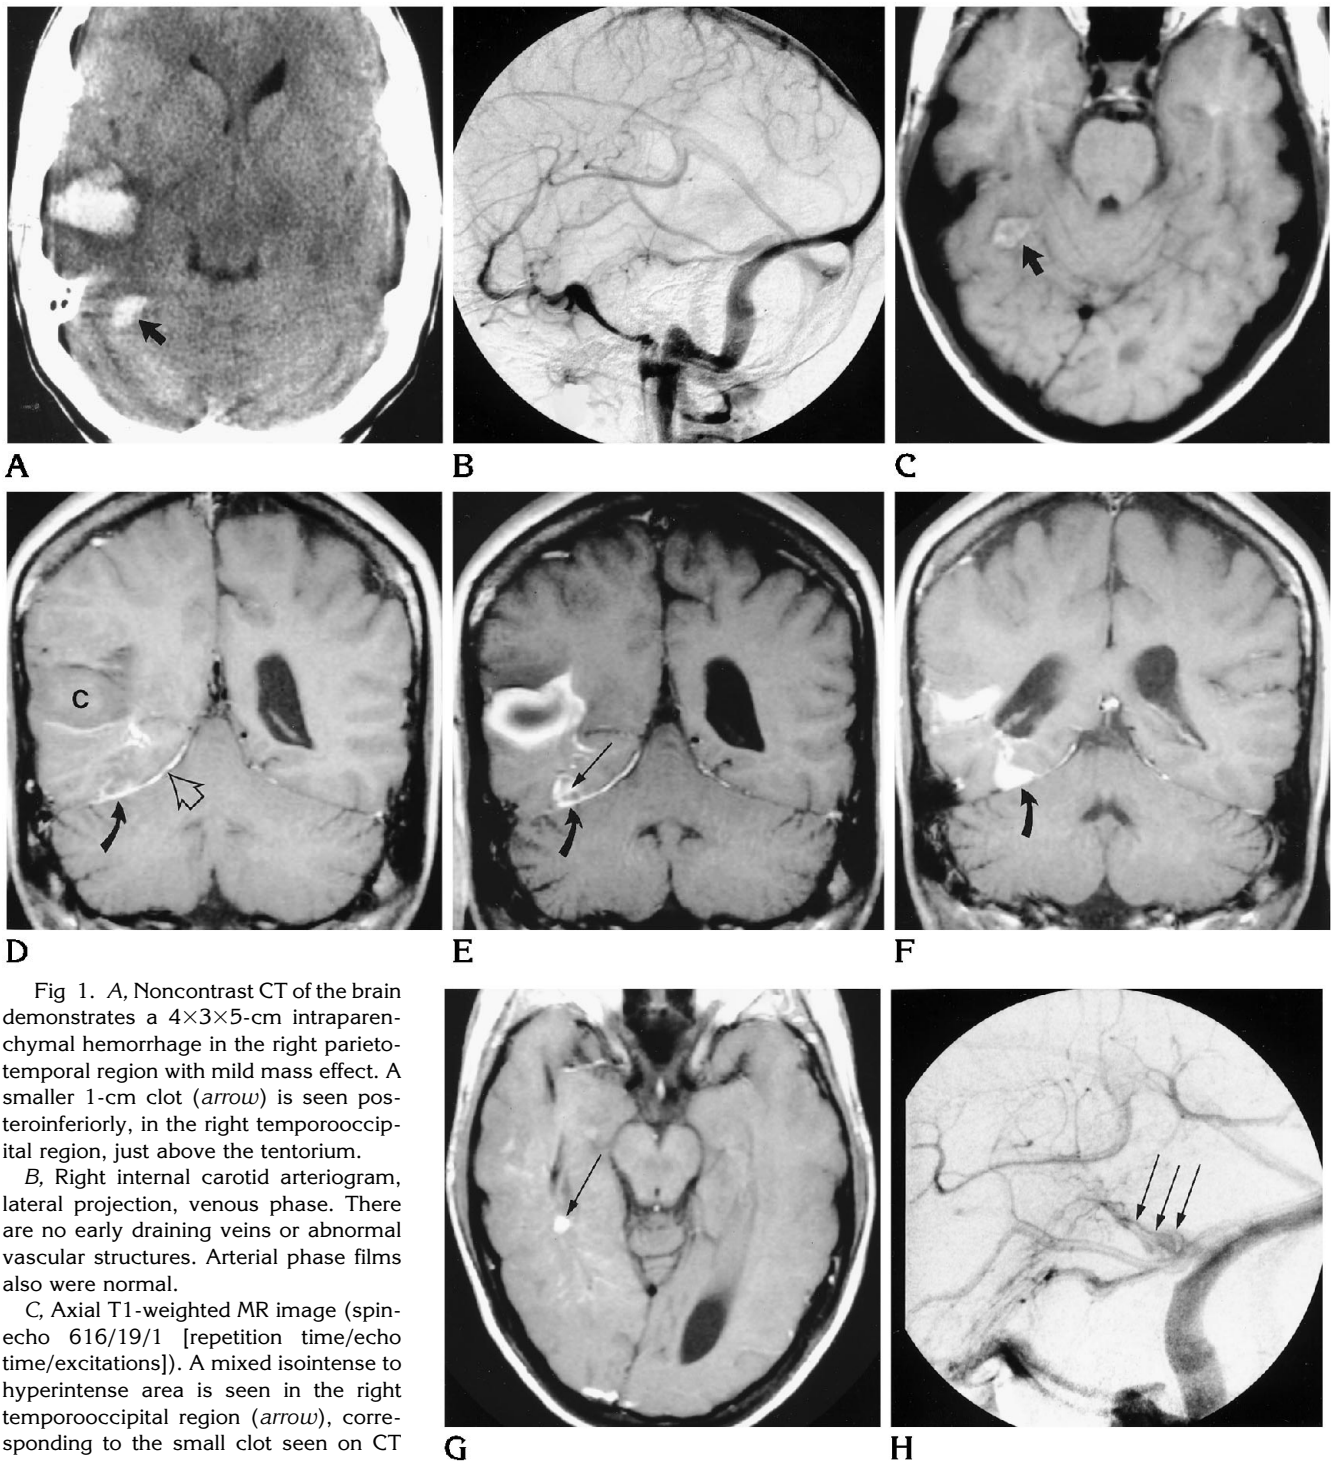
A, Noncontrast CT of the brain demonstrates a 4×3×5-cm intraparenchymal hemorrhage in the right parietotemporal region with mild mass effect. A smaller 1-cm clot (*arrow*) is seen posteroinferiorly, in the right temporooccipital region, just above the tentorium.
